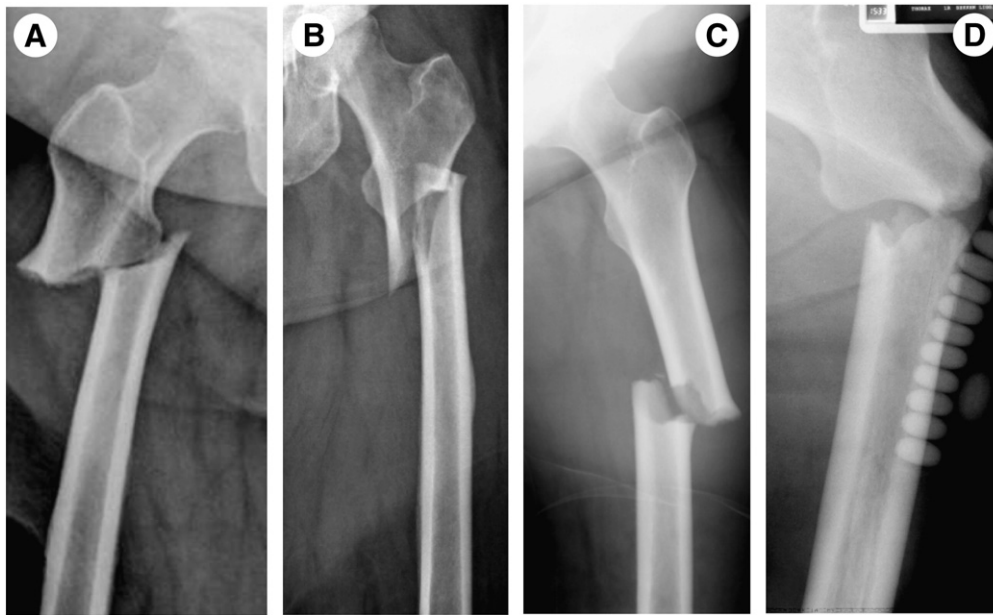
Representative radiographs of patients with atypical subtrochanteric (ST) and femoral shaft (FS) fractures treated or not with bisphosphonates: A) and B) atypical ST fractures in patients treated with bisphosphonates; C) atypical FS occurred in a patient who had discontinued pamidronate 5 years before the fracture; D) atypical ST in a man who has never been treated with a bisphosphonate.
